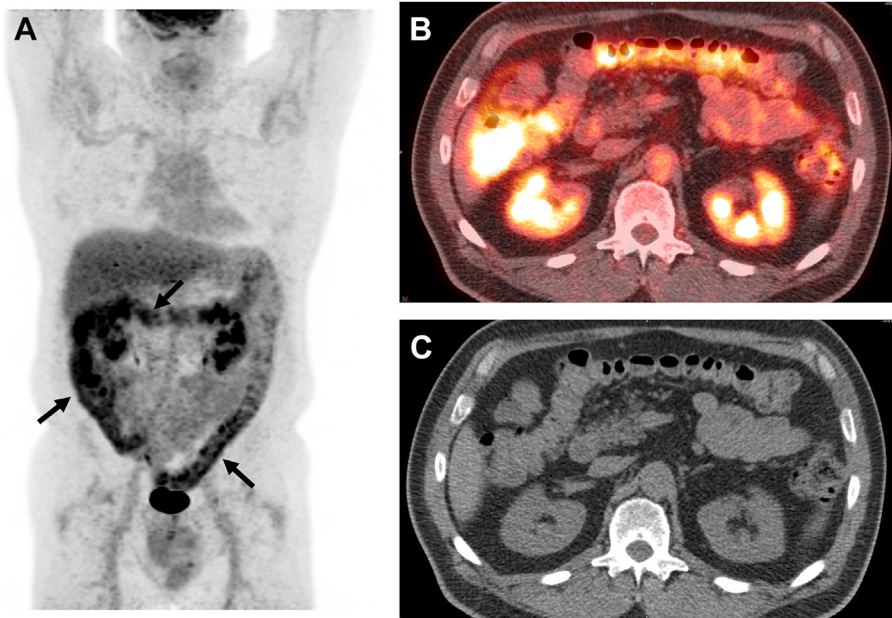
A 58-year-old-man with adenocarcinoma of the sigmoid colon diagnosed on a colonoscopy biopsy. The maximum intensity projection (A) and the transaxial images (B, C) show diffusely increased FDG uptake throughout the colon (arrows) that limits the detection of the primary site. The patient had type 2 diabetes mellitus and was taking metformin at the time of the ^{18}F -FDG PET/CT study.
